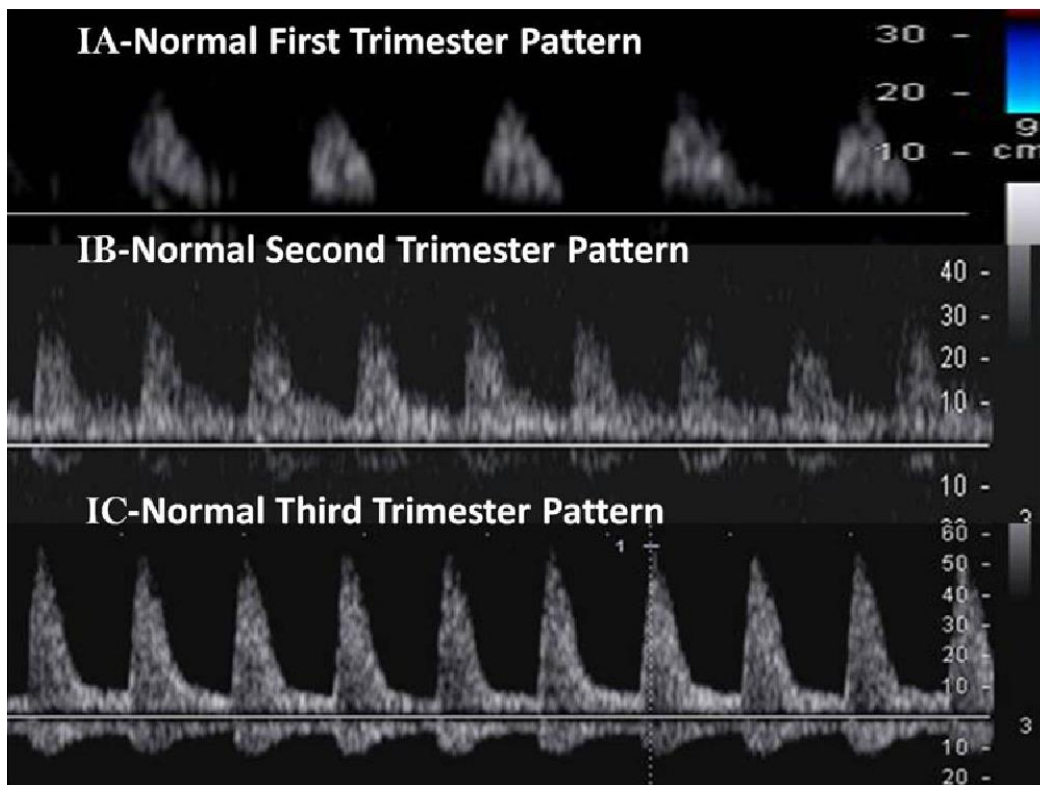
Normal middle cerebral artery doppler waveforms in 3 trimesters
